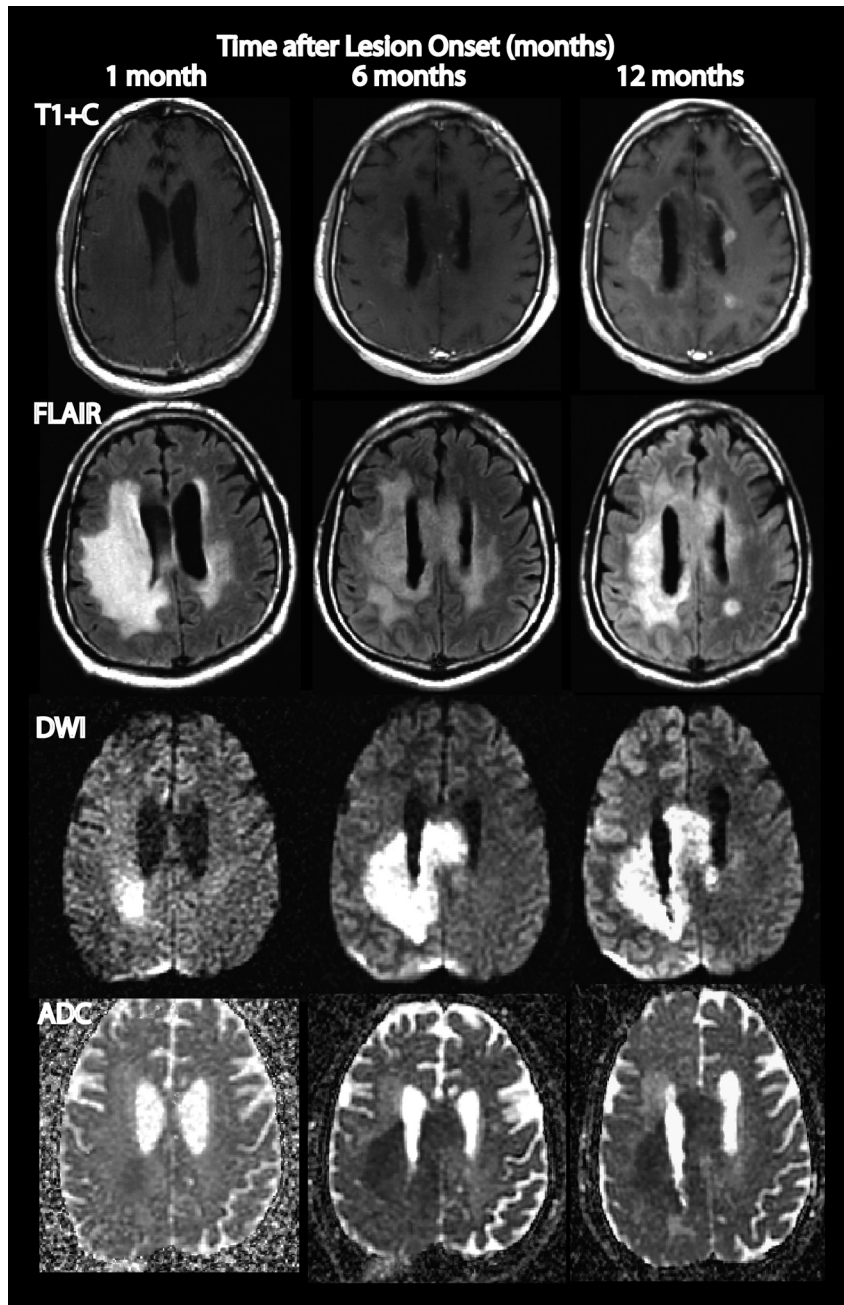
In a patient with glioblastoma with a well-defined and discrete diffusion-restricted lesion that developed before bevacizumab treatment, the lesion is shown at 1 month after its presentation and remains stable in size at 6 months and 1 year afterward. T1-weighted postcontrast image shows FLAIR hyperintensity and faint rim enhancement by 1 year.
